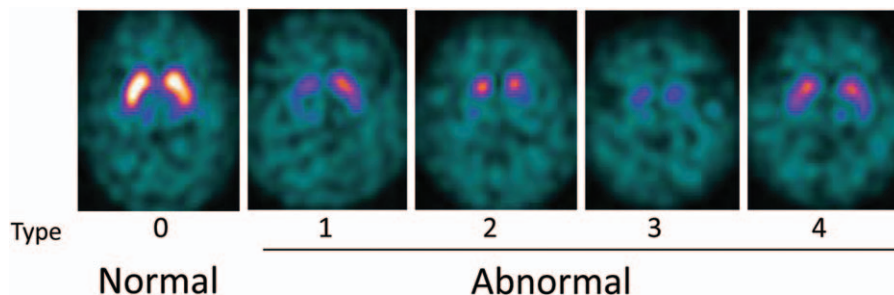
Reference I-123 FP-CIT SPECT images for visual evaluation. I-123 FP-CIT accumulations in the striata were categorized into 5 types (0–4). Type 0 was considered normal and types 1 to 4 were abnormal. FP-CIT = N- ω -fluoropropyl-2 β -carbomethoxy-3 β -(4-I-123 iodophenyl)nortropane, SPECT = single-photon emission computed tomography.
